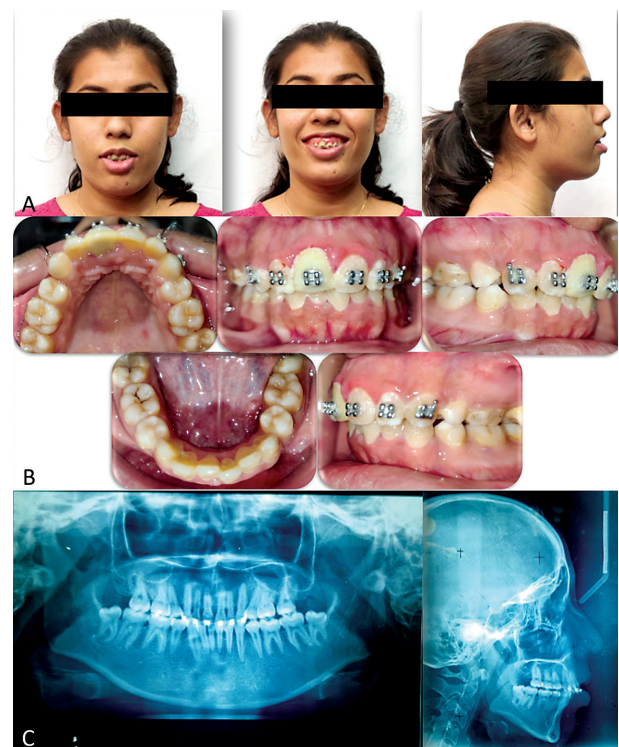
Pre-treatment photographs: (A), Extraoral photographs: (B), Intraoral photographs: (C), Radiographs.
